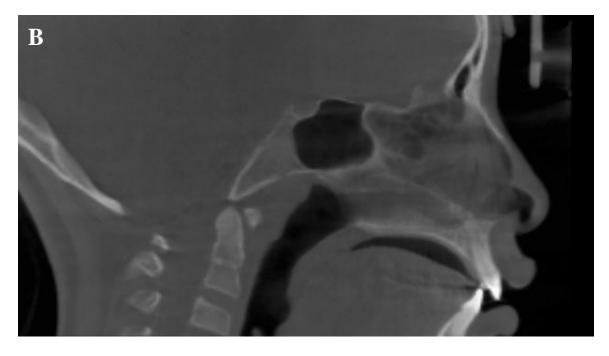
Pre-surgical (A) and post-surgical (B) CBCT scans demonstrating increased total airway volume
